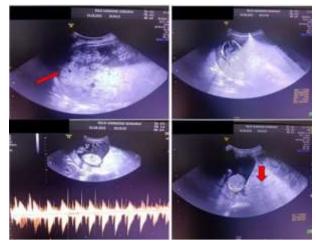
Ultrasound image of partial hydatidiform mole
